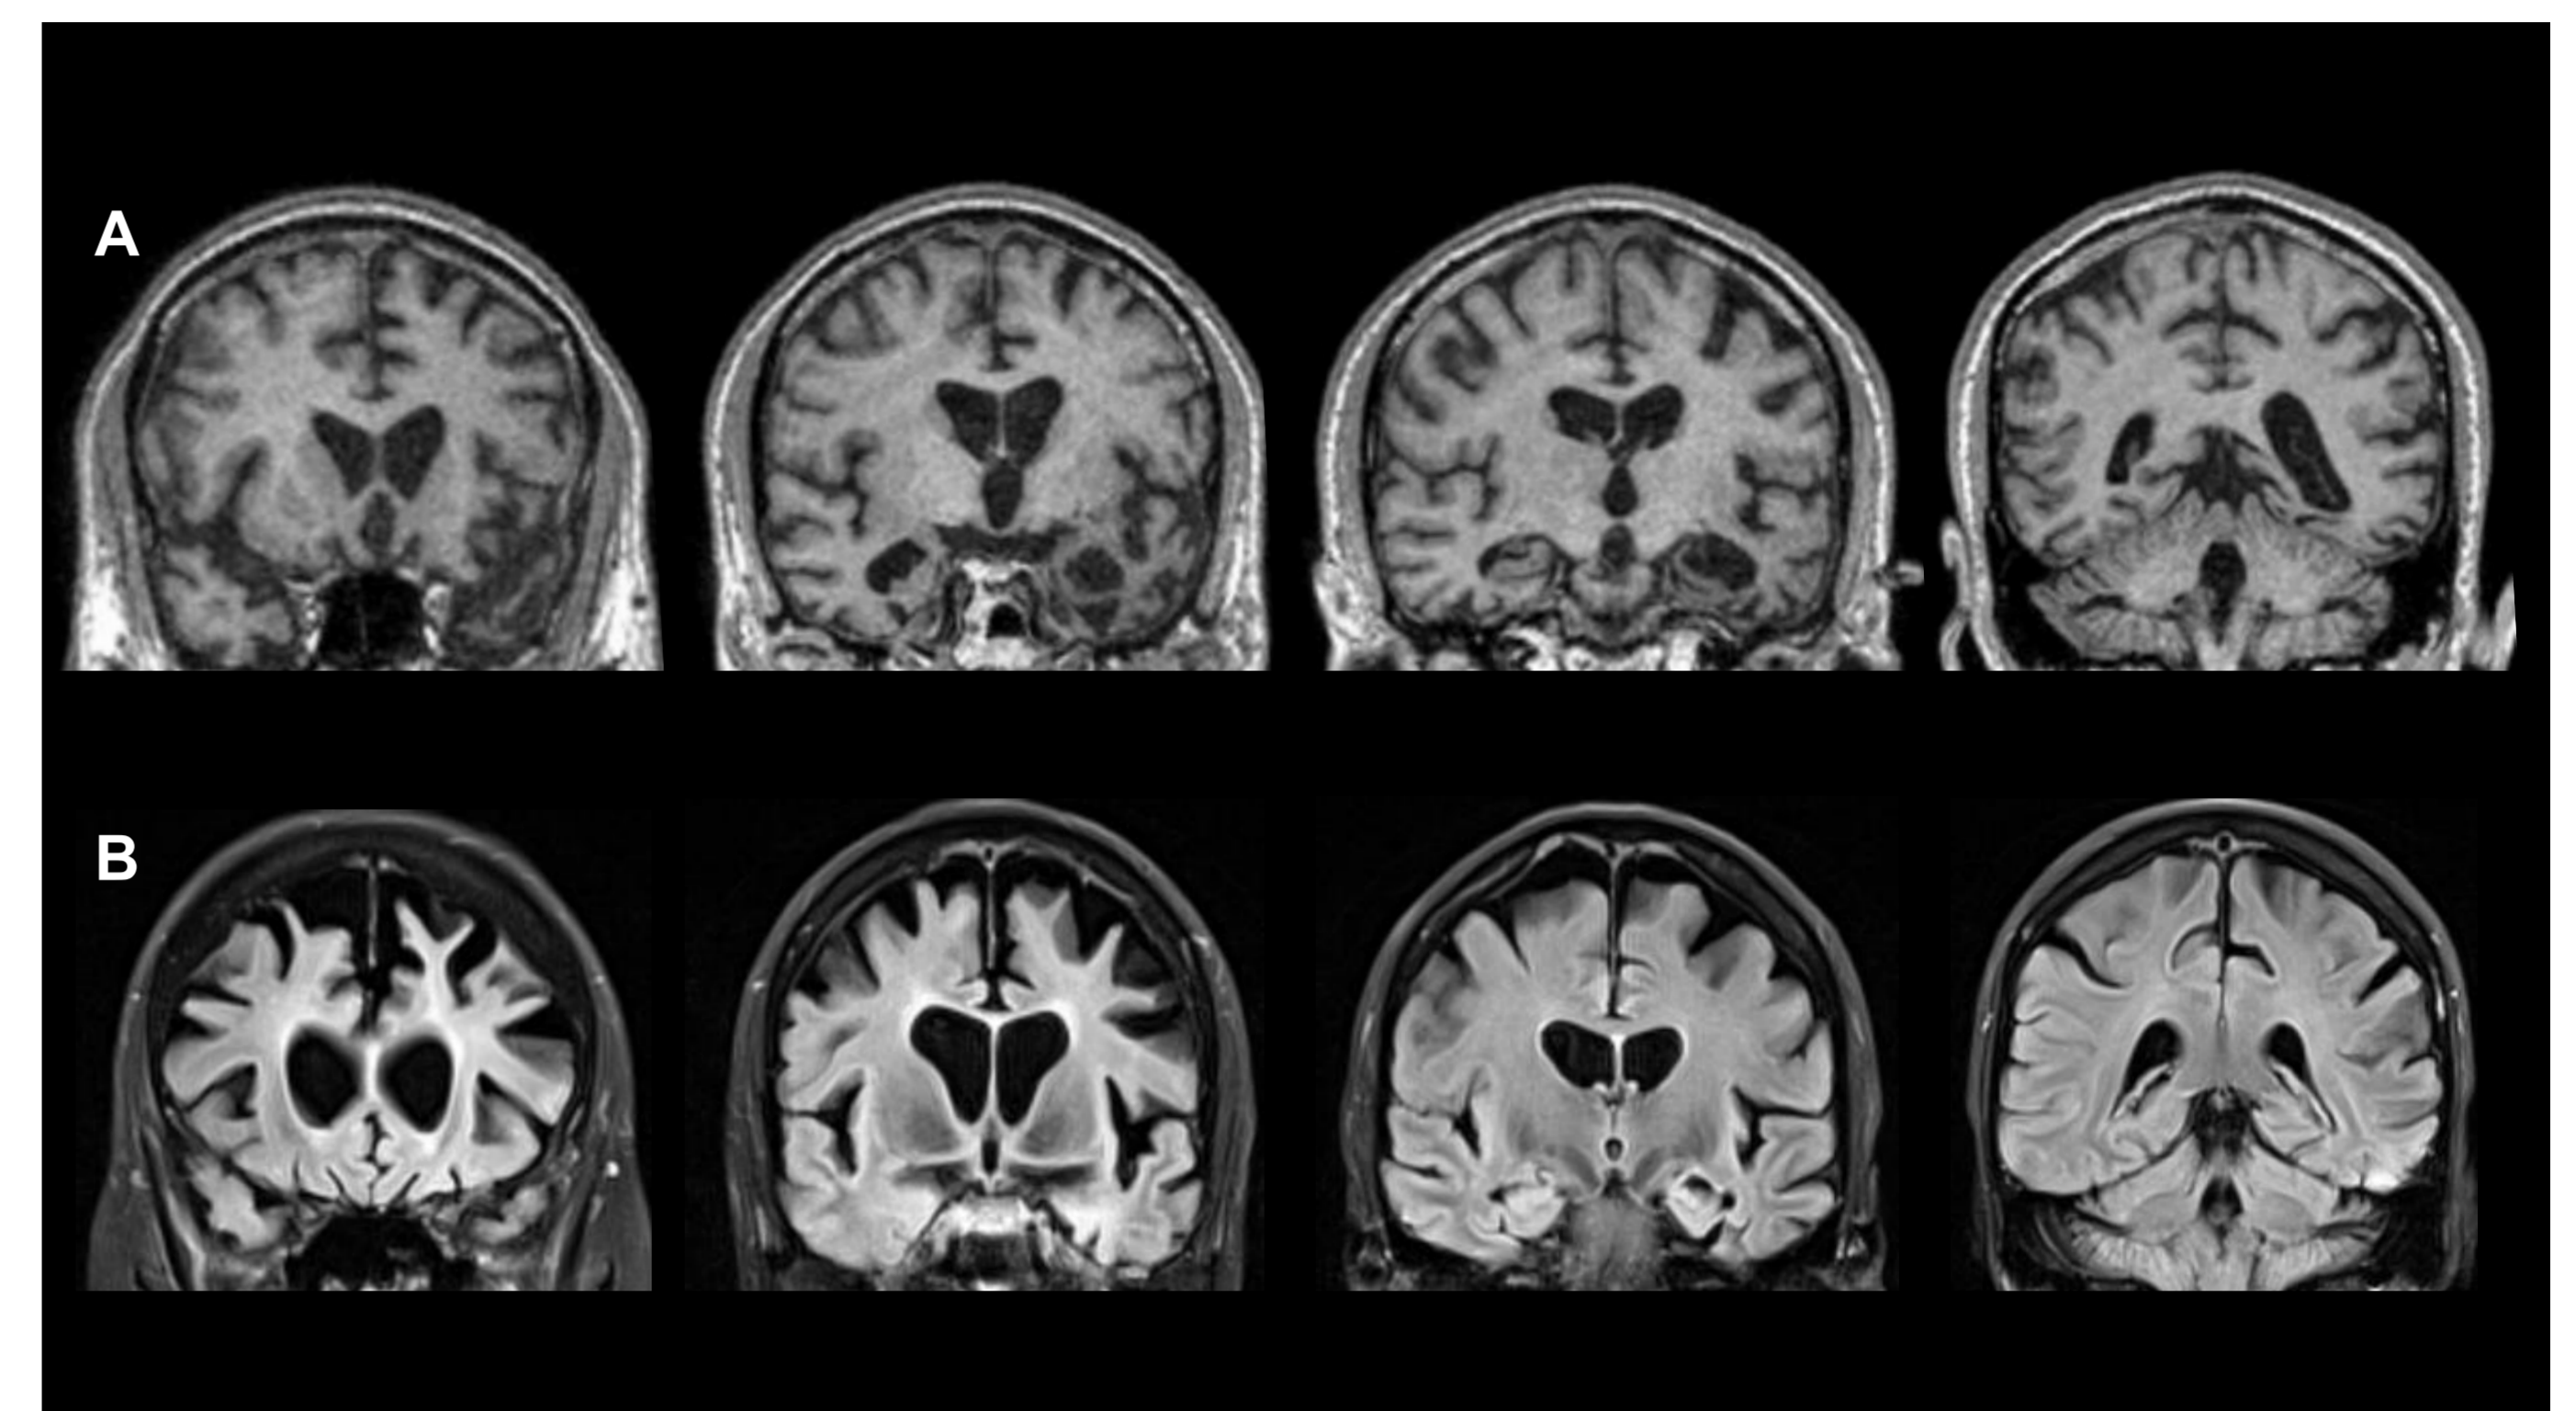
Coronal MRI scans of Case 1 (A) showing asymmetrical (left > right) temporal > frontal lobe atrophy, and Case 2 (B) showing relatively symmetrical frontal > temporal lobe atrophy
